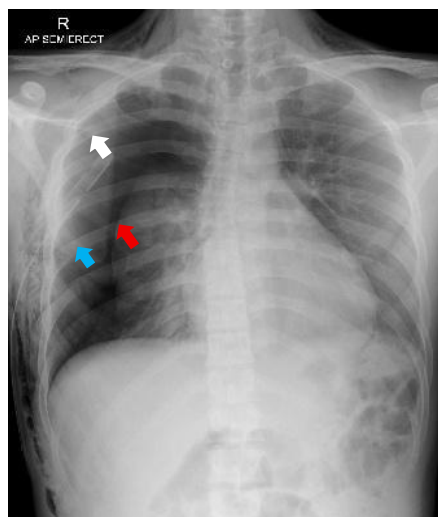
Chest X-Ray on Patient A: (a) Chest X-ray in posteroanterior (PA) position in the emergency room. (b) Chest X-Ray in the anteroposterior (AP) position, one hour after water-sealed drainage (WSD) treatment. (c) Chest X-ray in anteroposterior (AP) position showing a worsening condition of pneumothorax. (d) The lateral position on the third day shows a minimal air increase in the right pneumothorax. The avascular lucency region of pneumothorax (white arrow), the pleural visceral line (blue arrow) and the collapsed right lung (red arrow) are shown. Yellow arrow shows the WSD tube.
